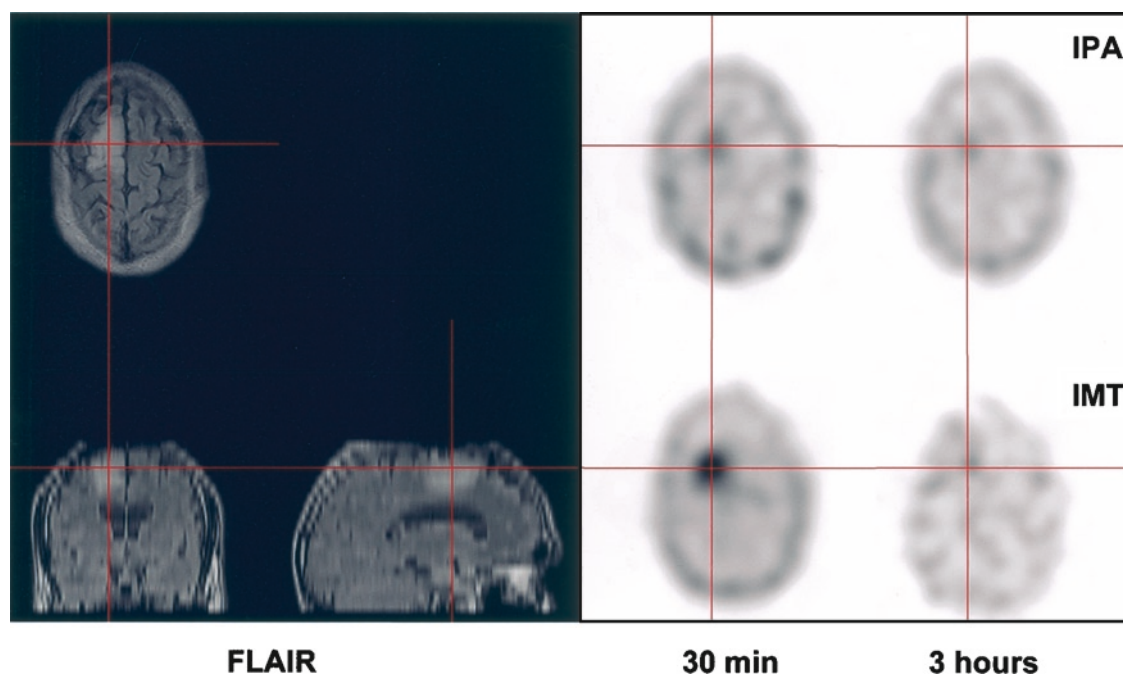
Intraindividual comparison of <sup>123</sup>I-IPA and <sup>123</sup>I-IPA in a patient with a low-grade glioma (oligoastrocytoma, WHO grade II) using early and delayed SPECT imaging. IMT-SPECT shows intense initial uptake with rapid wash-out, whereas IPA-SPECT demonstrates a lower but persistent retention in the brain tumour. No disruption of the blood-brain barrier was visible in NMR images after injection of contrast agent (not shown)
